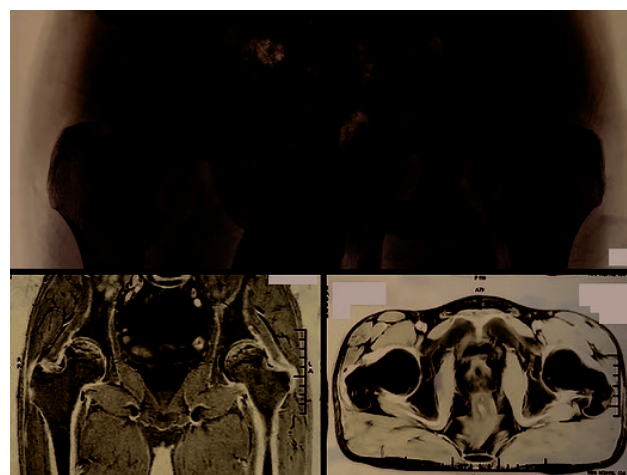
Upper panel: Radiograph of both hips showing sclerosis of both femoral heads and subchondral crescent sign. Lower panels: MRI images of both hips confirming Steinberg stage II/III osteonecrosis of femoral heads.
